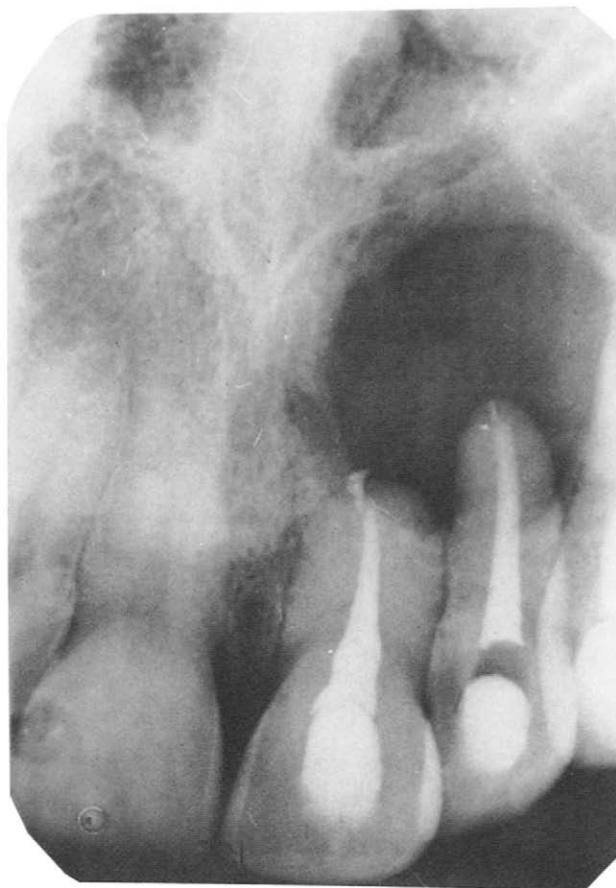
Radiograph of teeth 10 and 11 at the time of aspiration demonstrating increase in size of bony lesion.
